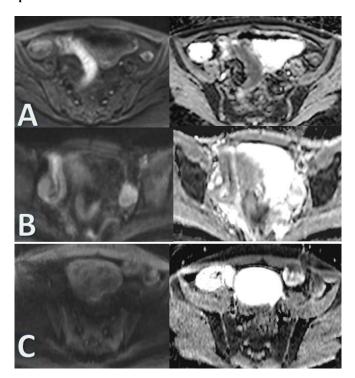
DWI grading; A&B :grade 3 (definitely present) mural thickness more than 3 mm with bright SI in DWI, dark SI in ADC of the terminal ileum. C: grade 0 (definitely absent) imperceptible wall and SI of the terminal ileum
